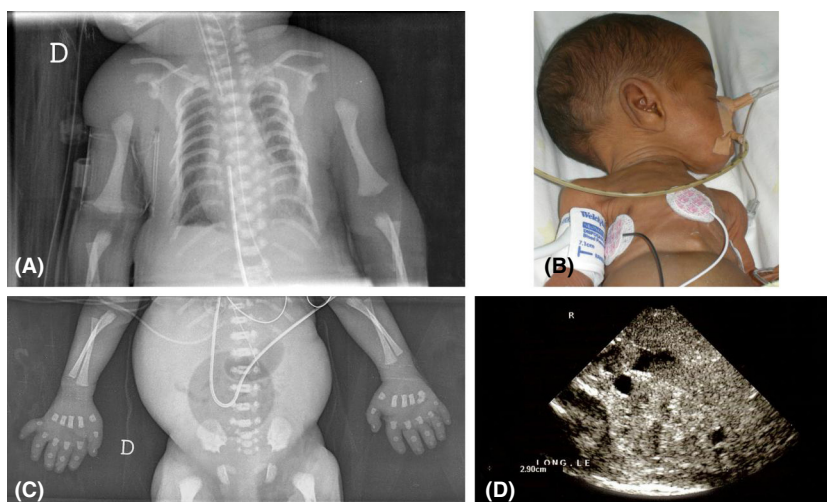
Clinical and radiological findings of the patient. (A and B) The narrow thorax with short ribs and hypoplastic lung. The arms long bones appear mildly shortened. (C) Postaxial hands polydactyly. At X-ray of the pelvis note the typical trident appearance of the acetabula. (D) Kidney ultrasound examination: note the cortical cysts, loss of cortico-medullary differentiation, and increased echogenicity.
